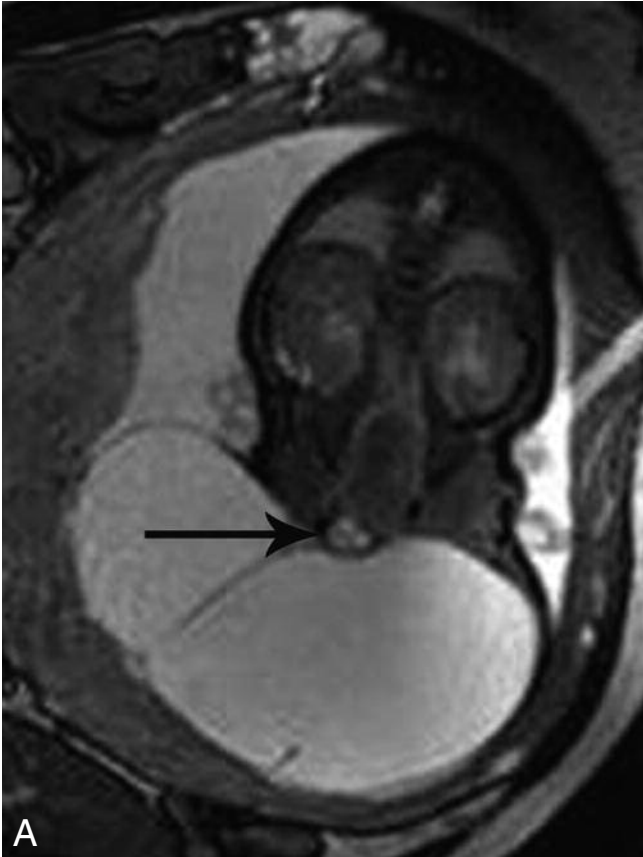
Prenatal MR imaging, coronal (A) and sagittal (B) T2 weighted images showing the liquid nature of the lesion and its expansive extra pelvic extension. The para rectal cyst is also well depicted (arrows).
